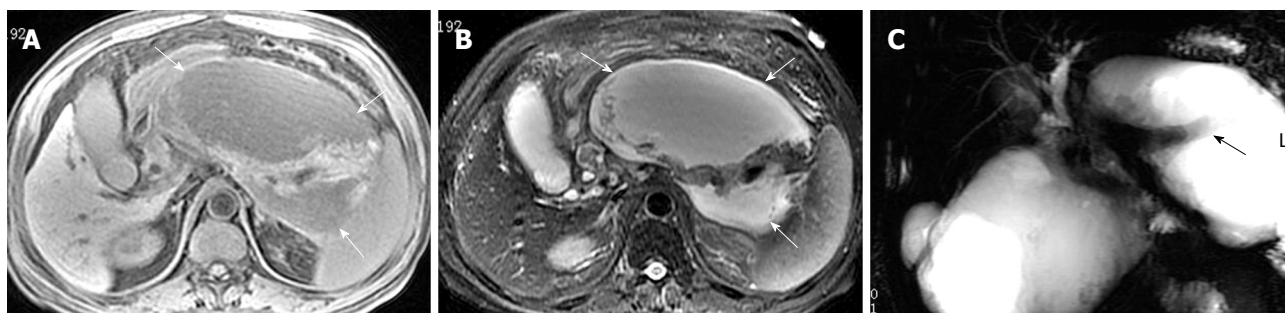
41-year-old man with a large peripancreatic pseudocyst who presented as abdominal distension for follow-up after acute pancreatitis. Unenhanced axial T1-weighted (A) and axial T2-weighted (B) images show a large lesion with typical liquid signal intensity around the pancreas (arrows). MRCP image (C) reveals the pancreas wrapped inside the large pseudocyst, just like the swimming fish (arrow).
